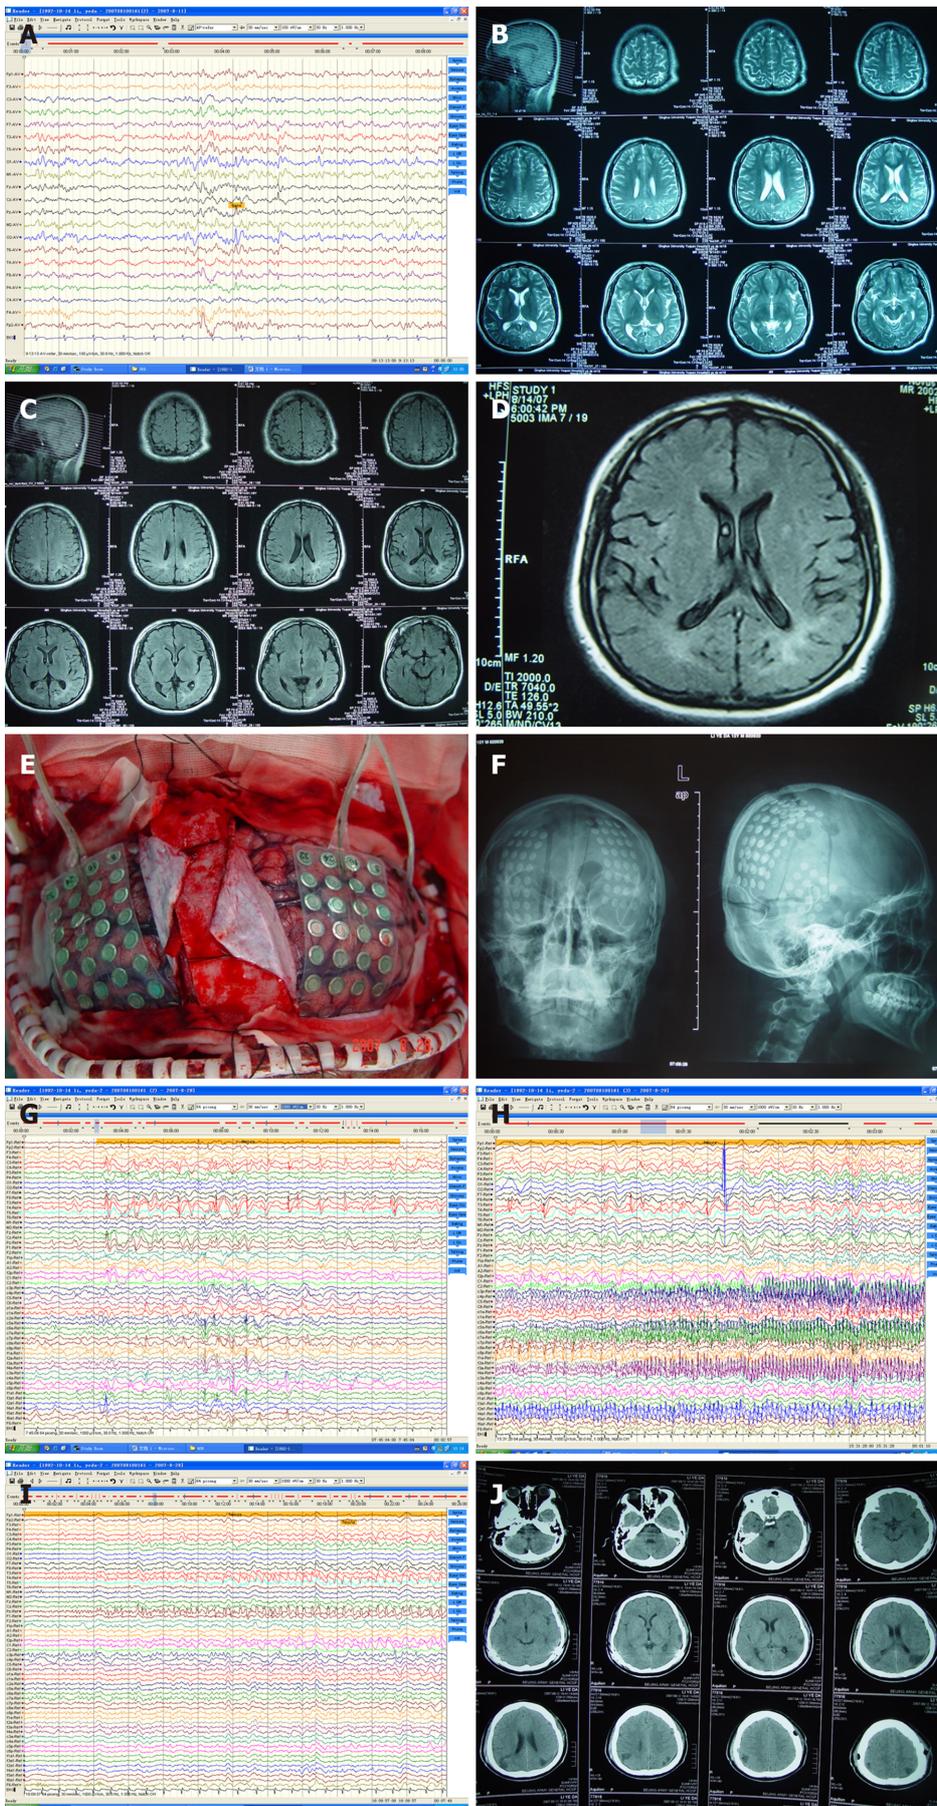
Clinical findings in a 15-year-old male patient with bilateral occipital lobe epilepsy. A: Scalp video-electroencephalography (EEG) recordings demonstrated abnormal discharges in the right occipital region during the interictal period; B and C: magnetic resonance imaging (MRI) revealed abnormal
